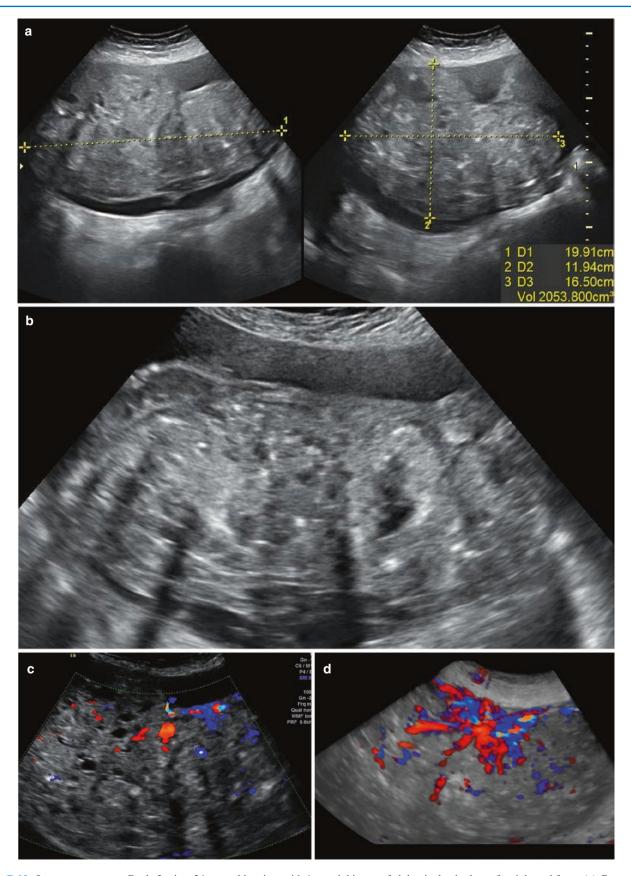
Immature teratoma Grade 3 - in a 24-year-old patient with 1 month history of abdominal pain, loss of weight and fever. (a) Greyscale shows a solid, heterogeneous mass (2053cc) with a lobulated external contour and ascitic fluid surrounding it. 1300cc of ascitic fluid was seen in the abdomen. (b) The mass is heterogeneous, shows few cystic spaces, some acoustic shadowing and scattered echogenic foci of calcification. Immature teratomas are known to be large with prominent, solid, heterogeneous components, that often show calcification. (c) Flow is seen in the mass (RI of 0.42). (d) 3D colour Doppler shows abundant flow within the mass. AFP was 2000 ng/ml (elevated). At surgery significant ascites and abdominal metastasis were noted
